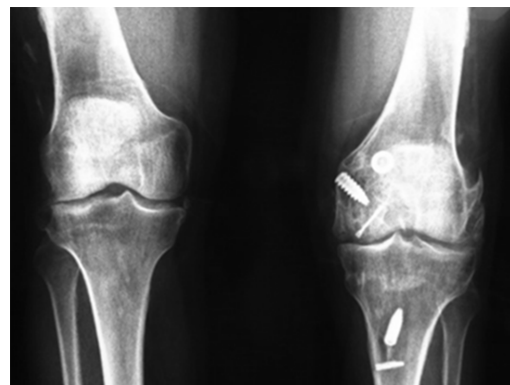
Anteroposterior knee x-rays for evaluation of arthritis progression (Kellgren and Lawrence grade 3).
